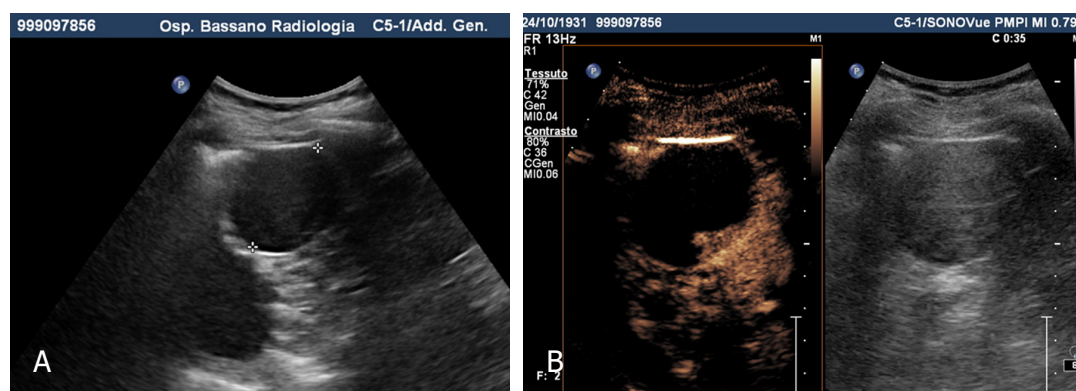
Bosniak 4 cyst. A: Grey scale shows hypoechoic round lesion with smooth margin; B: Contrast-enhanced sonography reveals a cystic lesion with mural nodules characterized by strong enhancement
